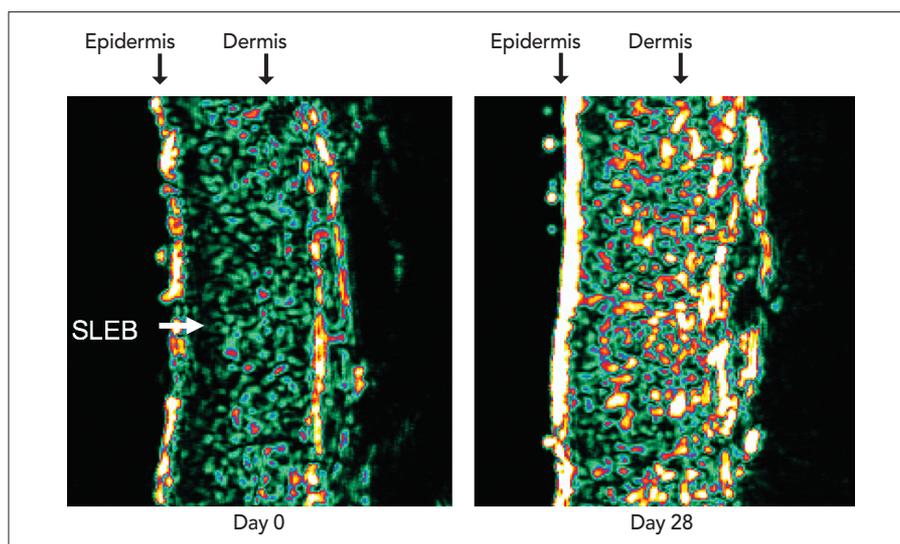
Ultrasonographic images of the forearm of a volunteer before and after treatment. Colour scale: white – yellow – red – green – blue – black; light colours indicating high echogenicity and thus high skin density.
